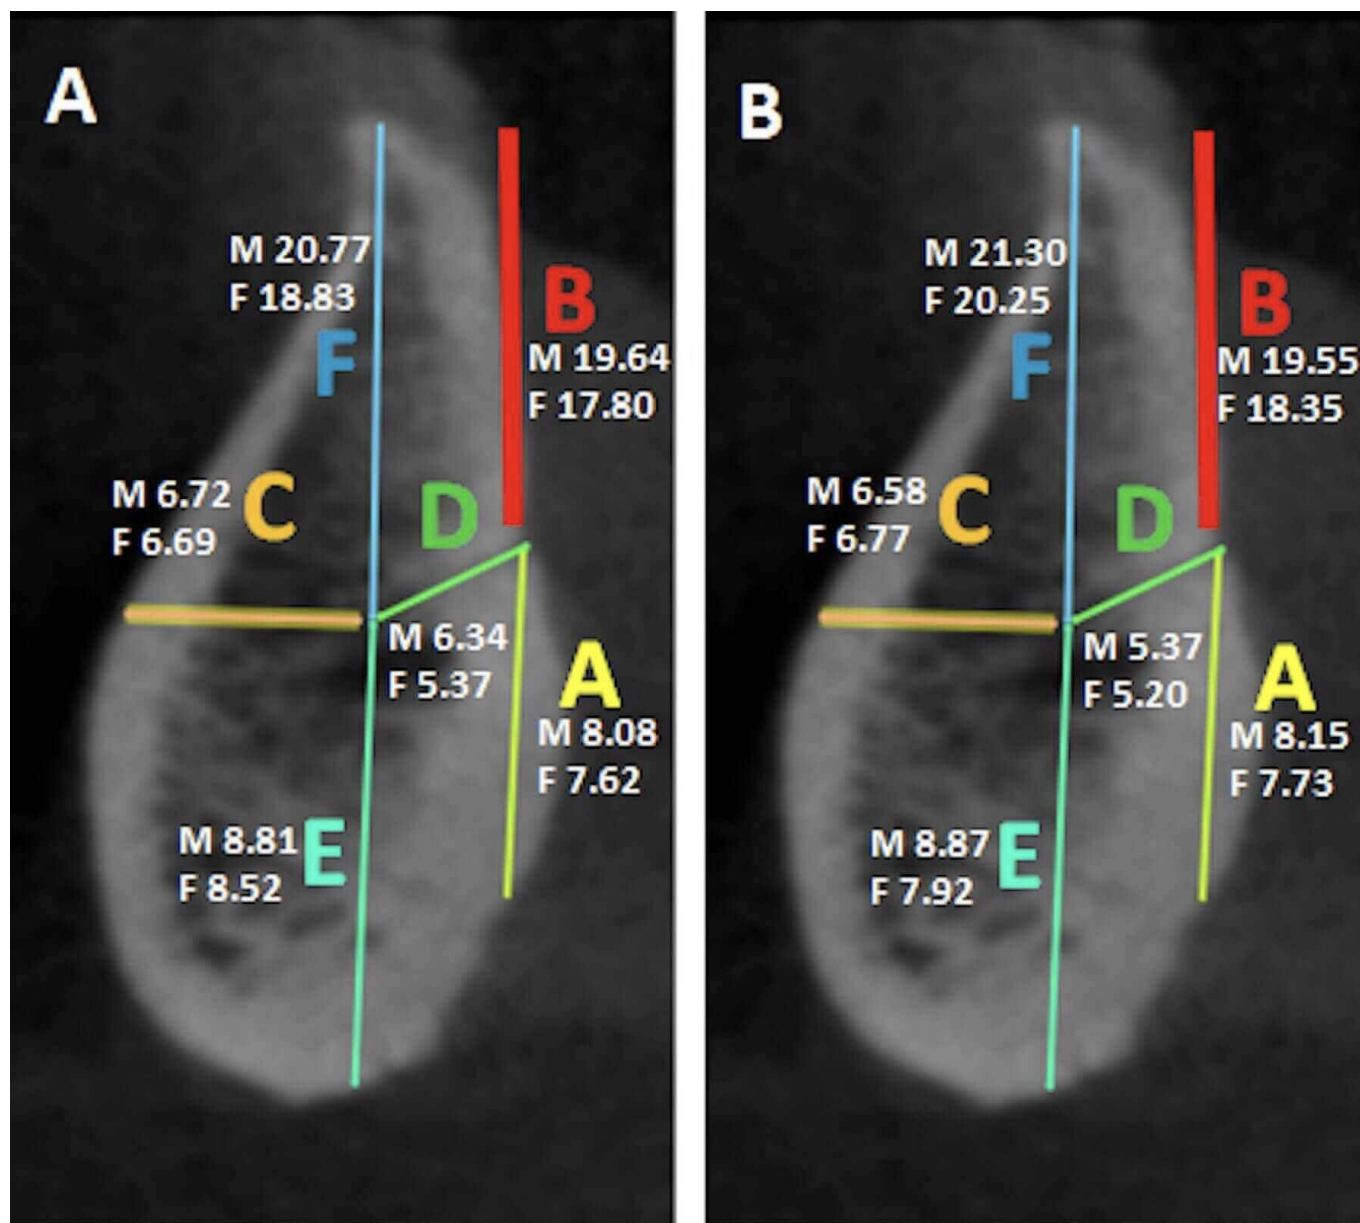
Cone-beam computed tomography (CBCT) in sagittal section of the mandible, representing the parameters analyzed for the lingual foramina. A- Mean values in males (M) and females (F). B- Median values in males (M) and females (F)
